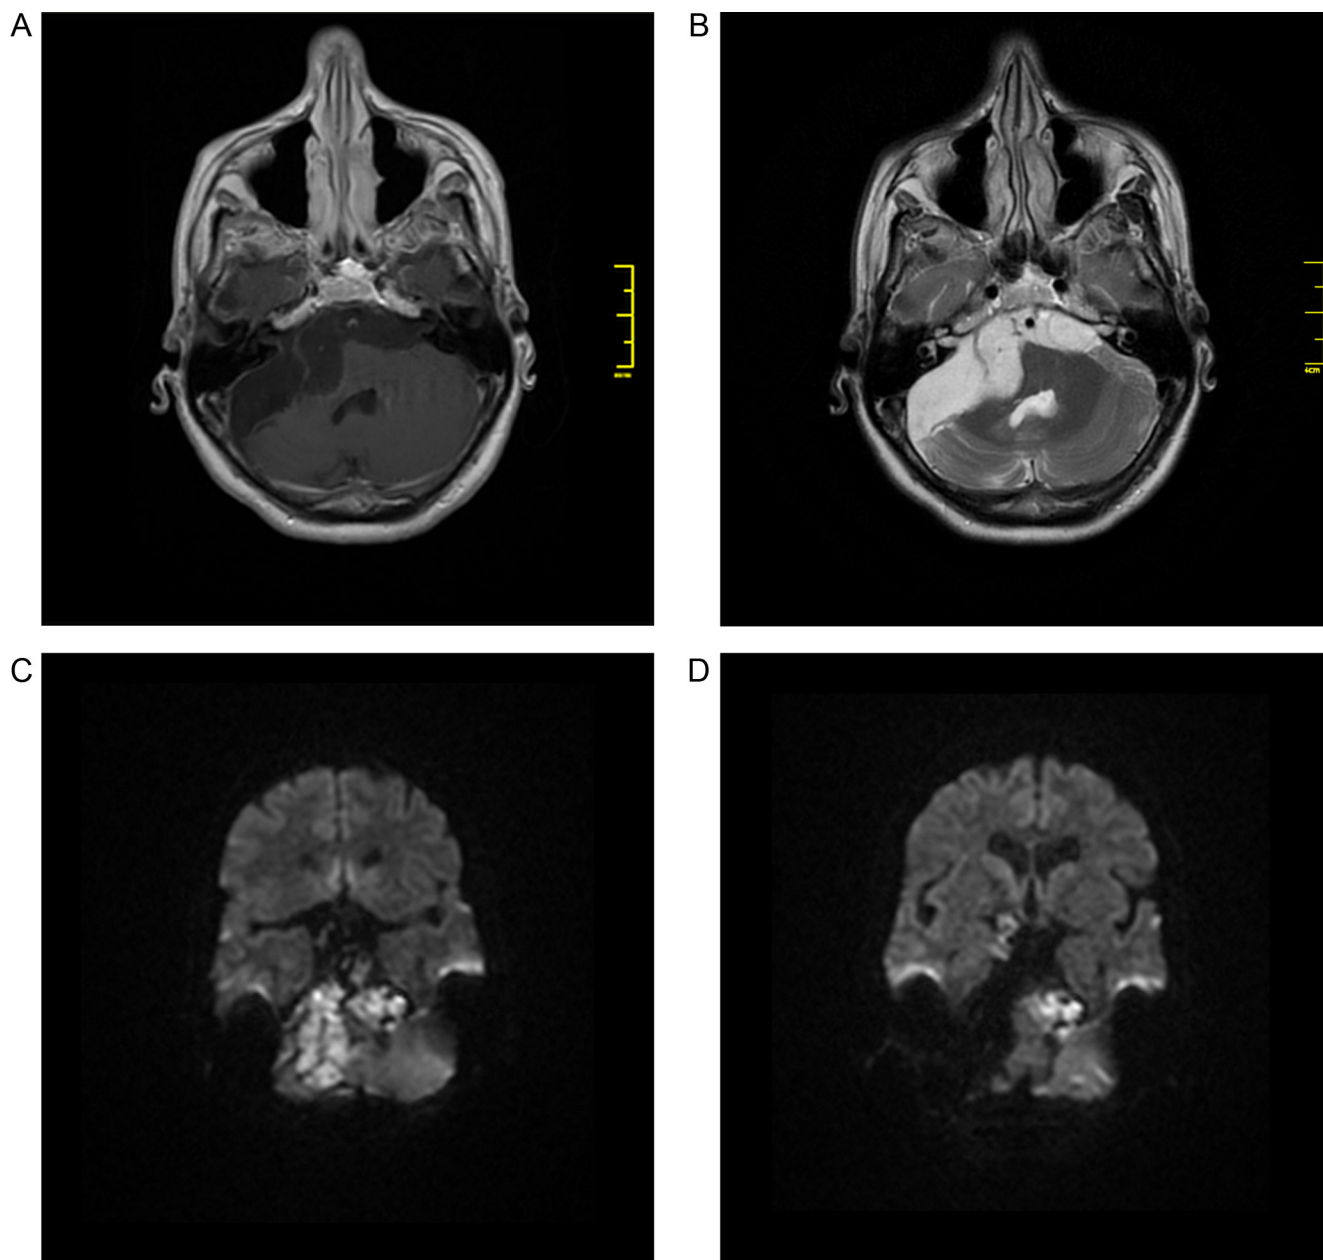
Preoperative MR examination in contrast enhanced T1-weighted (A) and T2-weighted (B) images as well as in DWI sequence (C) revealing epidermoid cyst located in the right cerebellopontine angle and extending along the skull base to the contralateral left cerebellopontine angle. After tumor removal in the first stage from the right side, patient did not consent to the second stage of surgical treatment and part of the tumor on the left side was stable during follow-up – MR image in DWI sequence (D).
